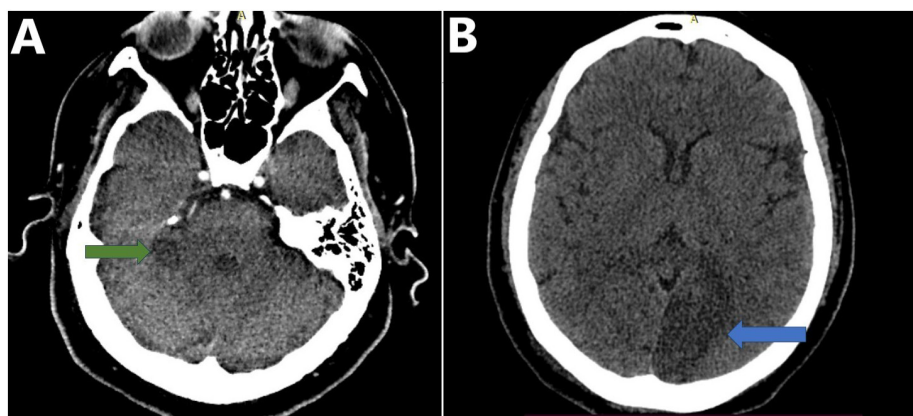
Computed tomography of the brain. (A) Ischemic stroke affecting the right cerebellum (green arrow). (B) Ischemic stroke compromising the left occipital lobe (blue arrow).
